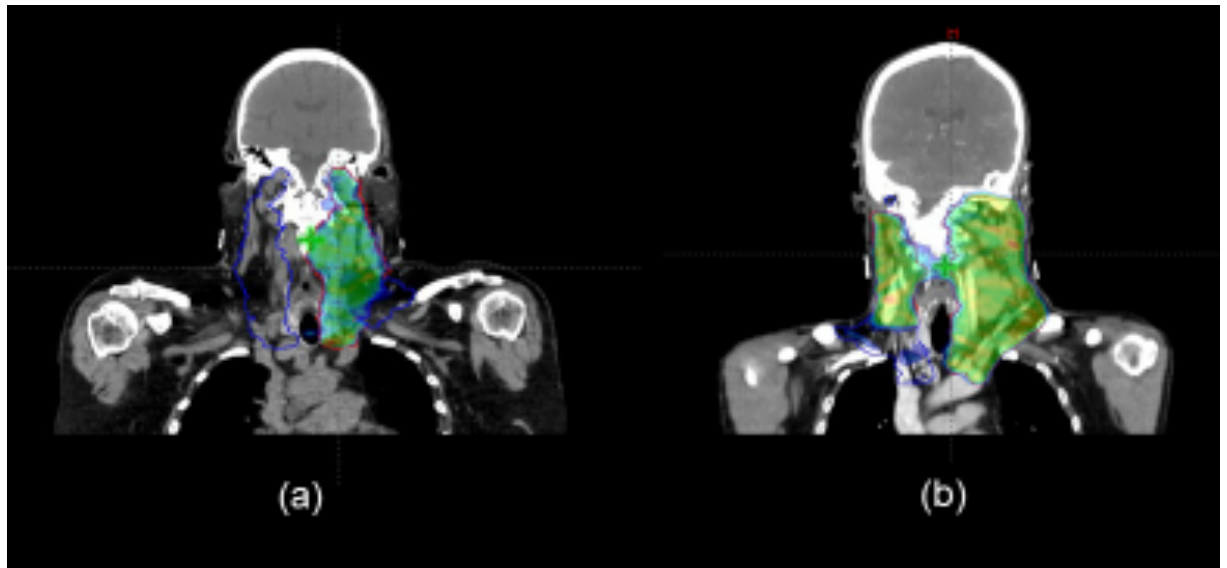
Example of nodal disease upstaging with PET/CT. In case of ipsilateral nodal disease the contralateral neck received a prophylactic dose of 54Gy (a). Patients with bilateral nodal disease received a full radical dose of 65Gy to the contralateral neck (b) with potential increased risk of radiotherapy related toxicity.
